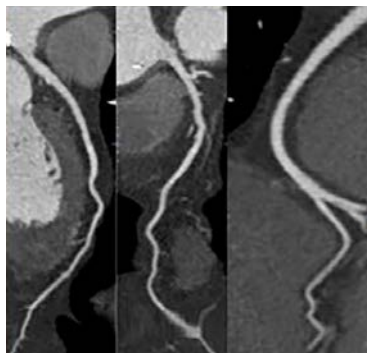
CT coronary angiogram. The images show no obstructive CAD in the left anterior descending artery (left), left circumflex artery (middle) or the right coronary artery (right).
